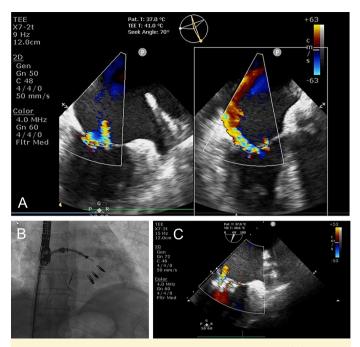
Initial TEE showed severe functional MR (A). Three MitraClips were successfully implanted (B) and a marked reduction was observed by TEE on the degree of MR at the final of the procedure (C). MR, mitral regurgitation; TEE, transesophageal echocardiography.
